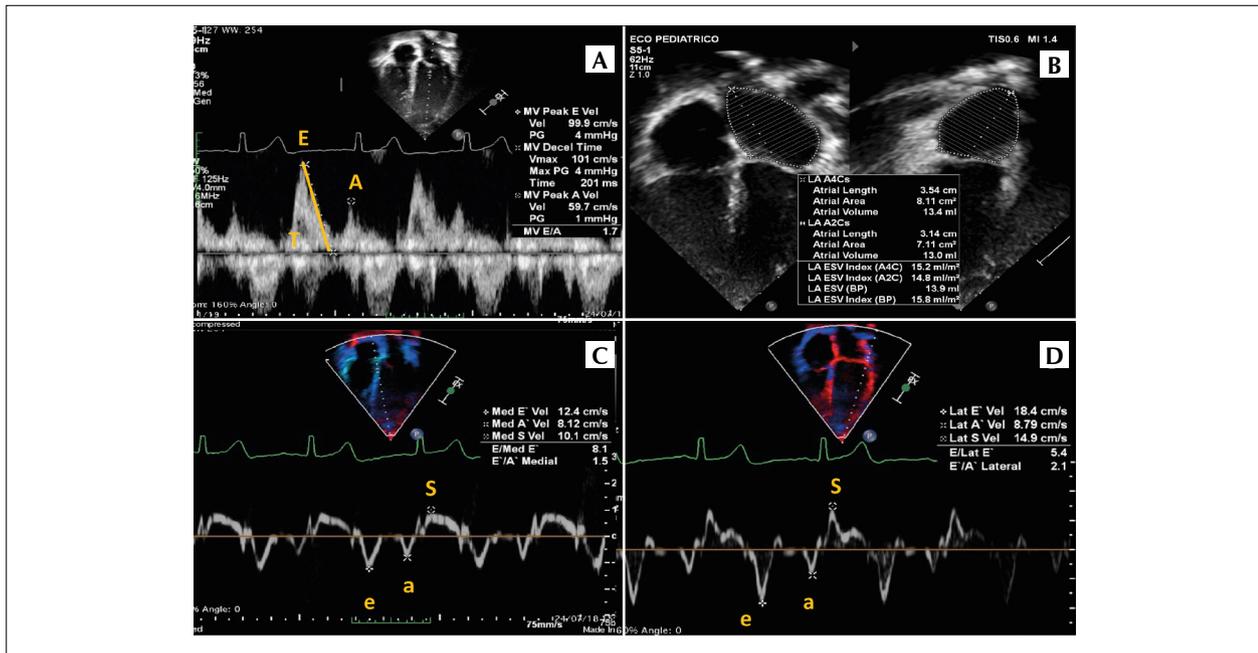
Left ventricular (LV) diastolic assessment. (A) Pulsed Doppler of mitral valve flow showing peak velocities during early ventricular diastole (E), atrial contraction (A), and deceleration time. (B) Left atrial volume assessment performed at the end of systole in the apical four- and two-chamber planes. (C) Tissue Doppler with septal mitral annulus velocities. (D) Tissue Doppler with mitral annulus velocities on the lateral wall of the LV.
